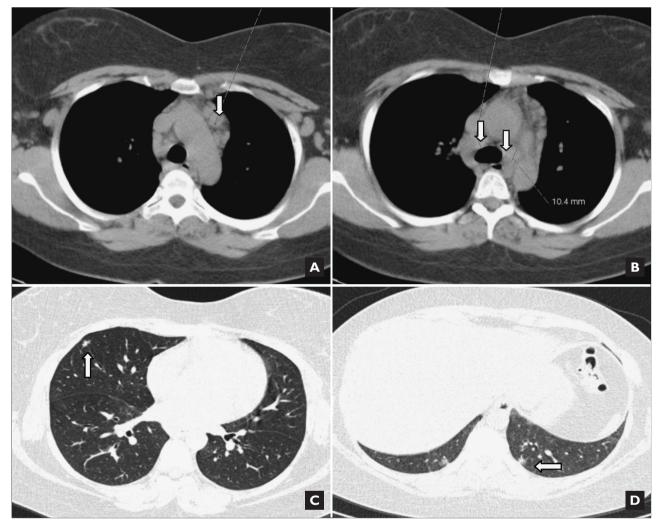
High resolution chest CT: multiple mediastinic adenomegalies (a, b), the largest with 13 mm short axle in preaortic topography (a); some random-distribution small peripheral nodules, some with ground-glass halo and poorly defined limits (c, d).
